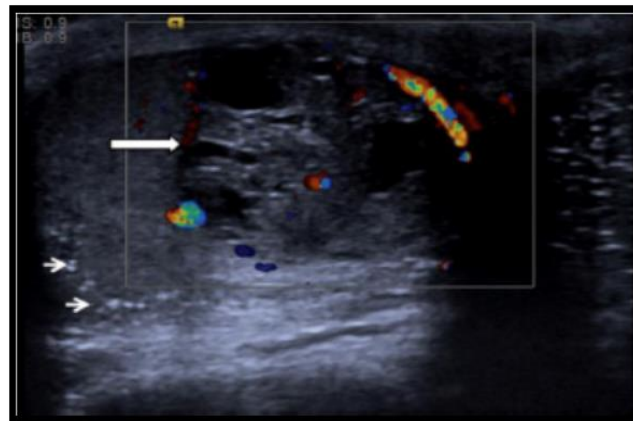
shows the mixed germ cell tumor appears as focal lesion with heterogeneous reflectivity and cystic components (long arrow). Color Doppler demonstrates distortion of the normal vascular pattern by the lesion. Note is also made of background testicular microlithiasis (short arrows)(Ercan et al, 2007).
